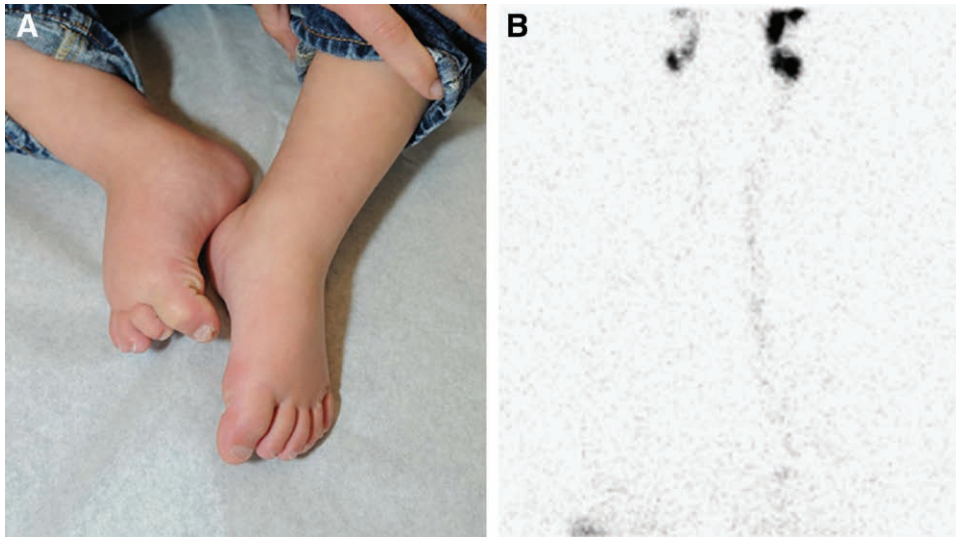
A, Resolution of right foot swelling at 12 months of age. B, Lymphoscintigram image 30 minutes after injection of radiolabeled tracer into the feet showing tracer uptake in the right inguinal nodes consistent with normal lymphatic dysfunction.
